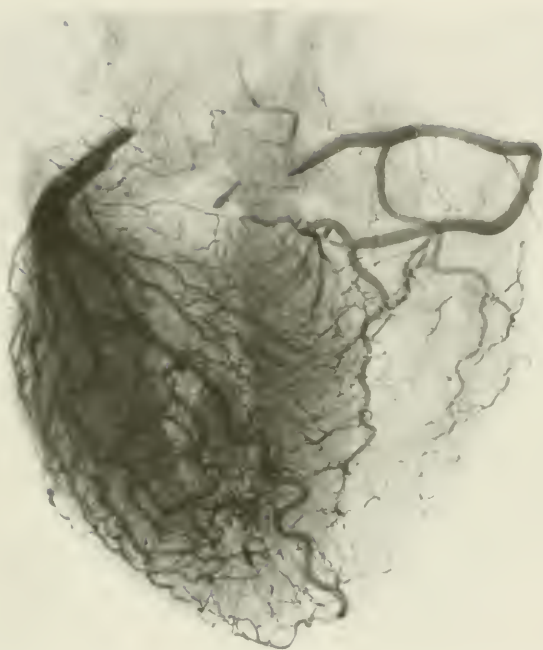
Roentgenogram of the blood supply in the average heart of the seventh decade.
